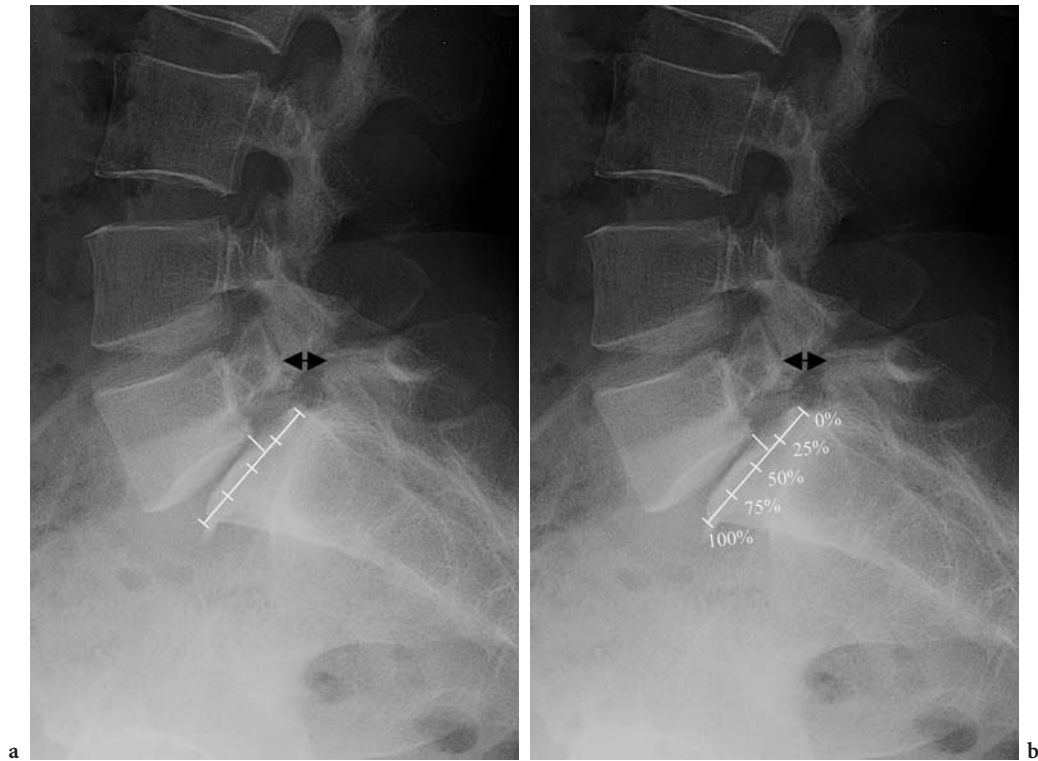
Methods of grading lumbar spondylolisthesis. The method of Meyerding (a): lateral radiograph of the lumbar spine in type 2b isthmic spondylolisthesis (double arrows) shows a grade II slip. The method of Taillard (b) in the same patient shows an approximately 35% slip
